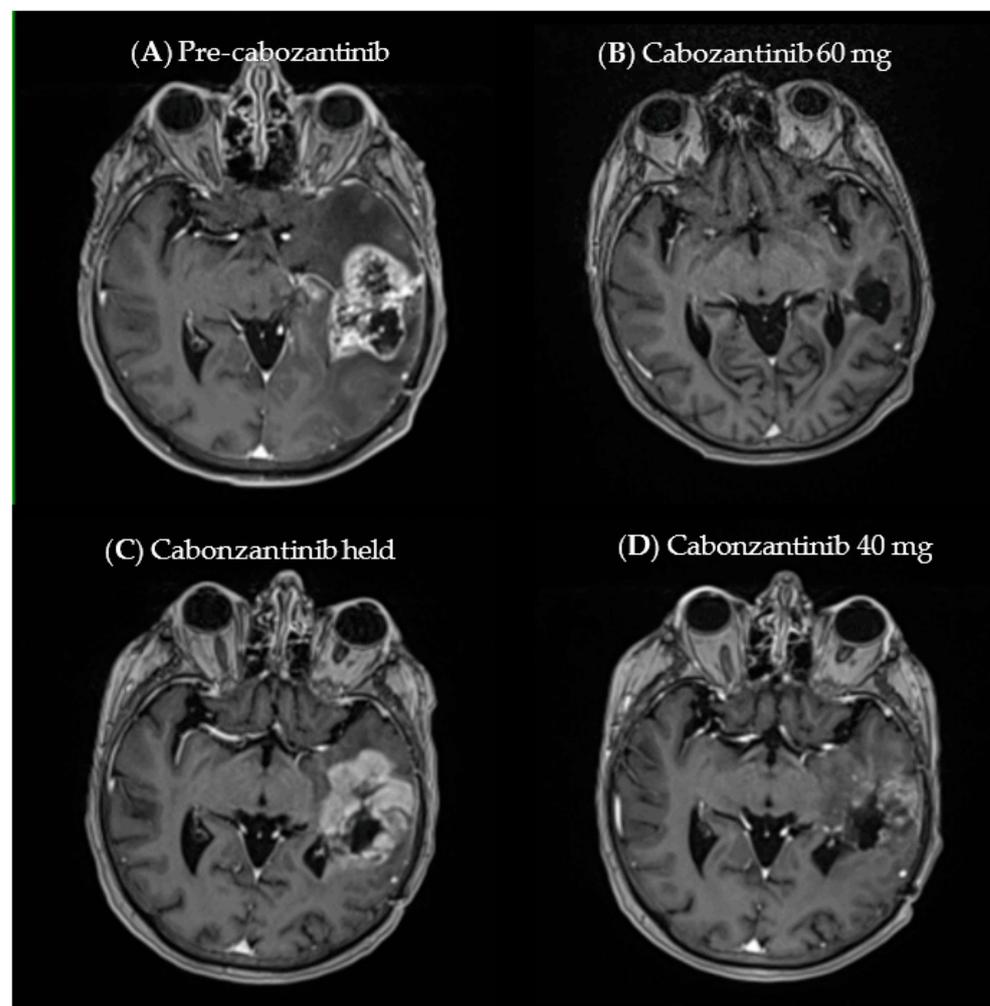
(A) Baseline MRI scan at progression. (B) MRI scan at four weeks following cabozantinib, revealing complete response. (C) After four weeks of maintaining cabozantinib, the MRI scan revealed progression. (D) After four weeks of dose-reduced cabozantinib, the MRI scan revealed a partial response.
